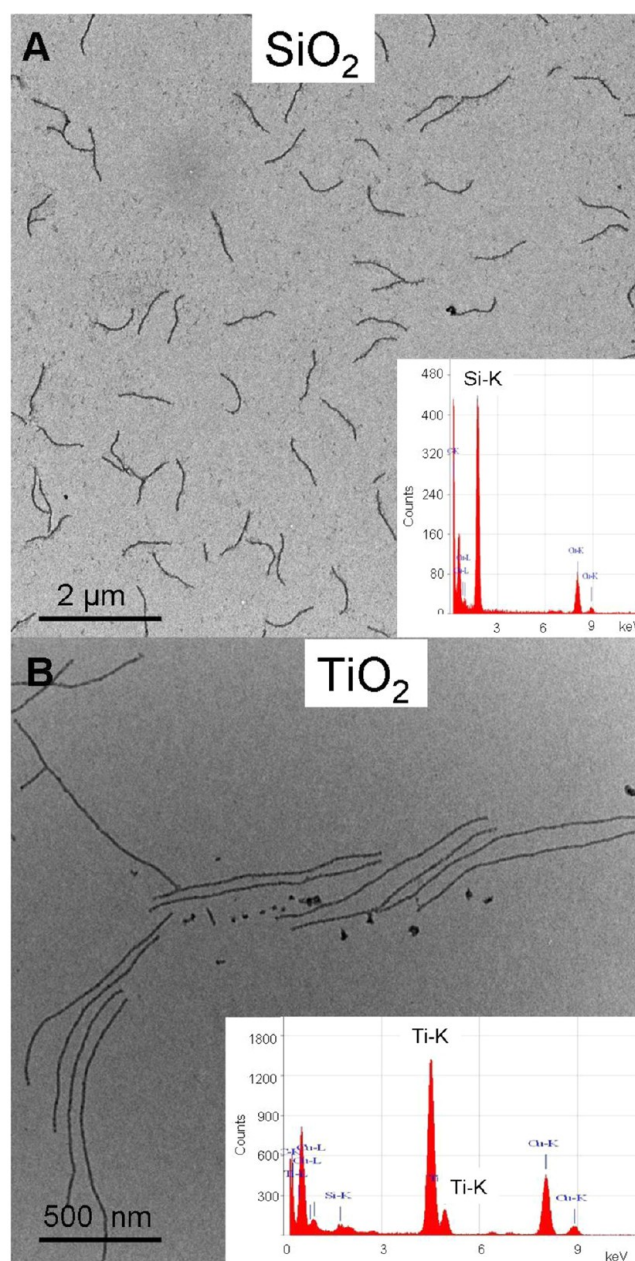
(A) Hybrid virus/SiO₂ and (B) virus/TiO₂ rod-like particles. TEM images and energy dispersive X-ray analysis confirming the presence of SiO₂ and TiO₂ on the viral rod-like particles respectively. The high contrast of the particles is induced by the presence of the mineral shell on the viruses.
